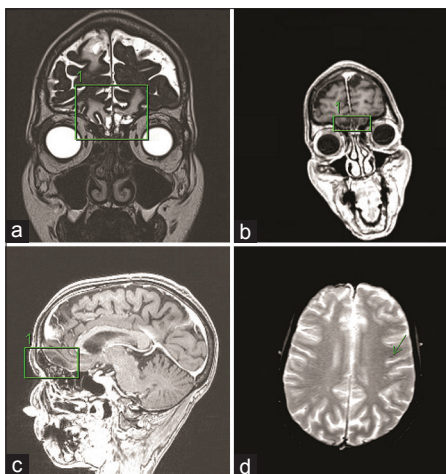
Delayed MRI exam: (a) Coronal T2 encephalomalacia (b) coronal films showing encephalomalacia (c) sagittal image showing frontal encephalomalacia (d) small GRE heme
